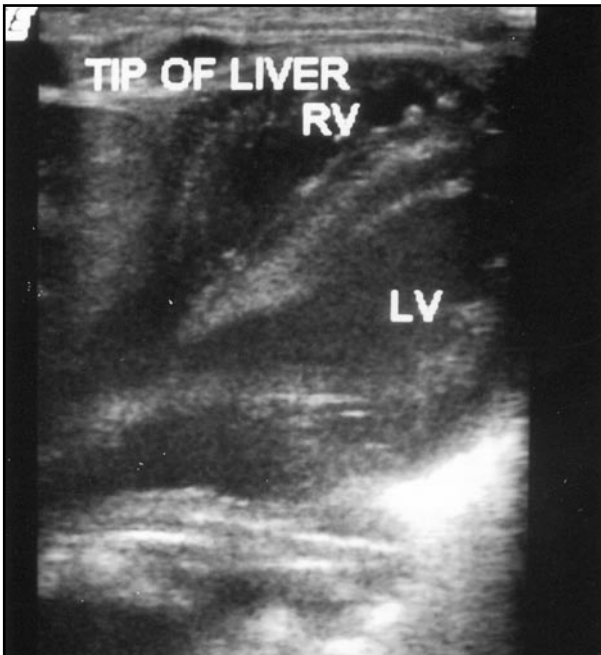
Post operative chest ultrasound showing the liver herniation
